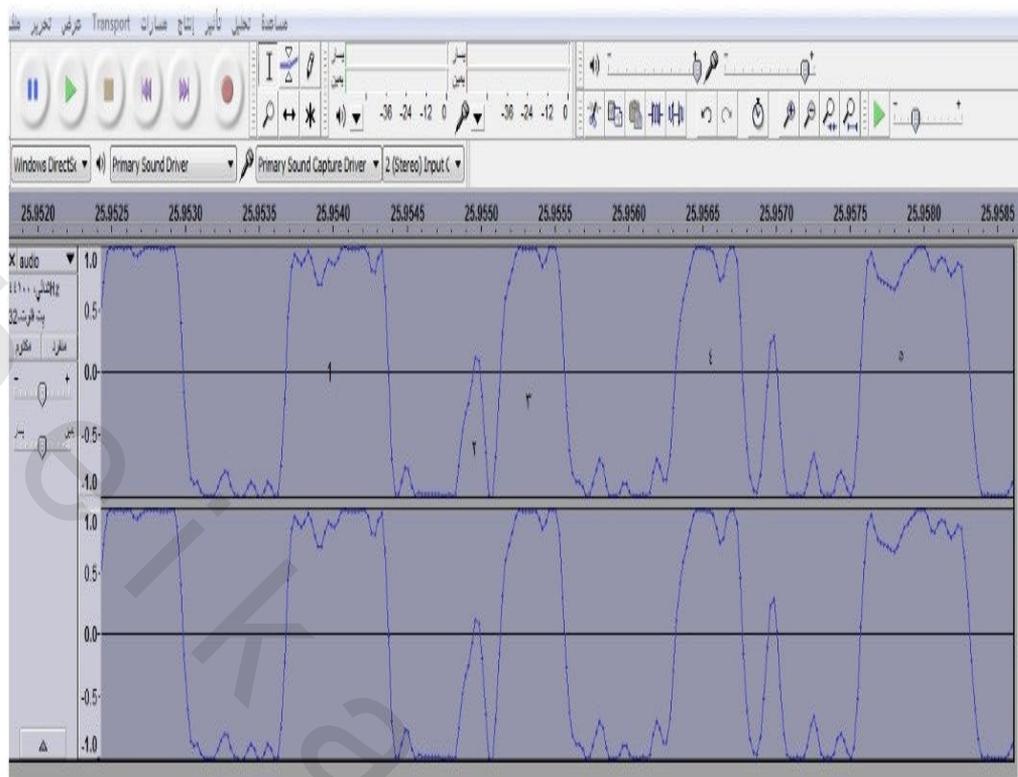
Showing fully expanded MRI waveform bands labold 1 to 5. Bands 1,2 3, and 4 are the characteristic sound of the used MRI.
